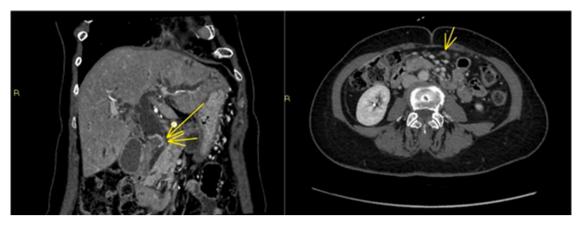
[Case 3 - CT Abdomen] Imaging at the time of diagnosis showing pathologic enhancement in the distal common bile duct and suspected pelvic peritoneal metastasis.
